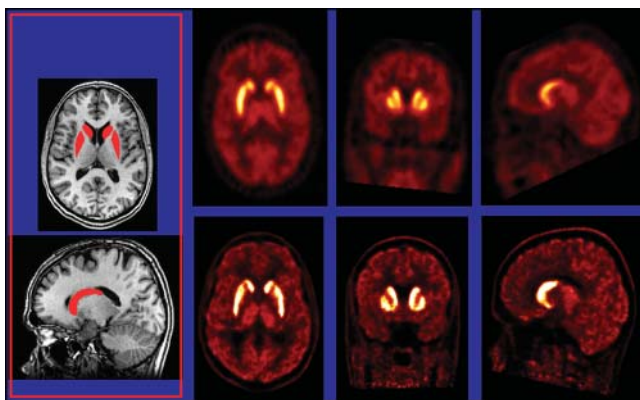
A high-spatial-resolution PET camera for imaging the neuronal dopamine transporter with ^{11}C -PE2I added important information when overlaid on corresponding MR images (left). The new PET camera produces a volume resolution of $16\ \mu\text{L}$ (right, bottom) and, in contrast with PET images with volume resolution of $2.5\ \mu\text{L}$ (right, top), shows a clear separation in the parts of the striatum.
